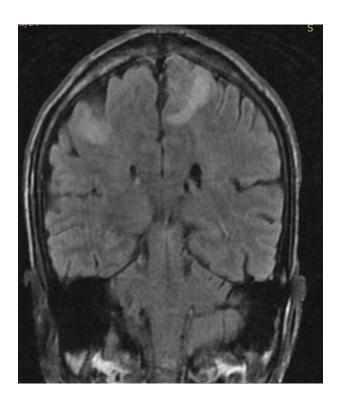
There are multiple symmetrical patchy areas of T2/FLAIR hyperintensities seen in cortical, subcortical area of bilateral frontoparieto occipital region (Image A, B and D). Also, there is patchy areas of hyperintensities of right cerebellum (Image C), which is uncommon location of involvement in posterior reversible encephalopathy syndrome.
